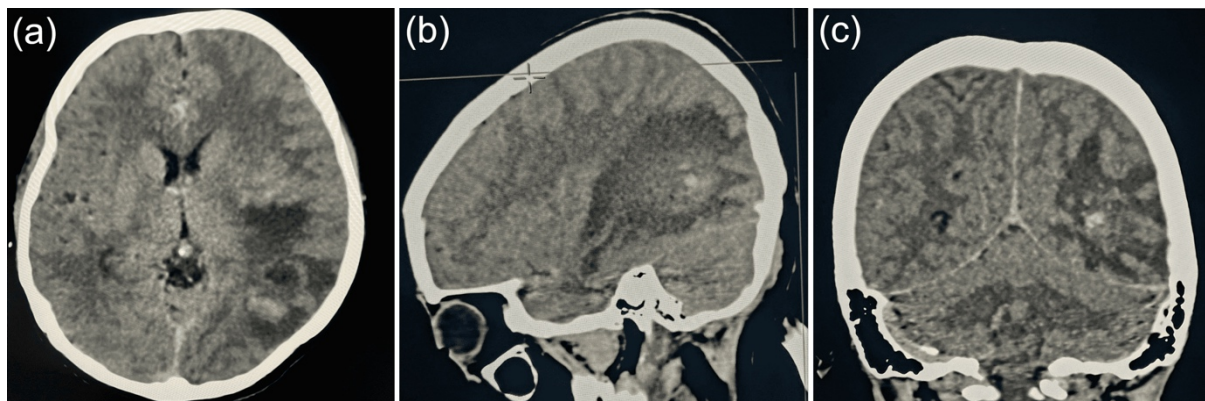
Brain Computed Tomography Scan Showing Brain Abscess in (a) Axial View, (b) Sagittal View, and (c) Coronal View
